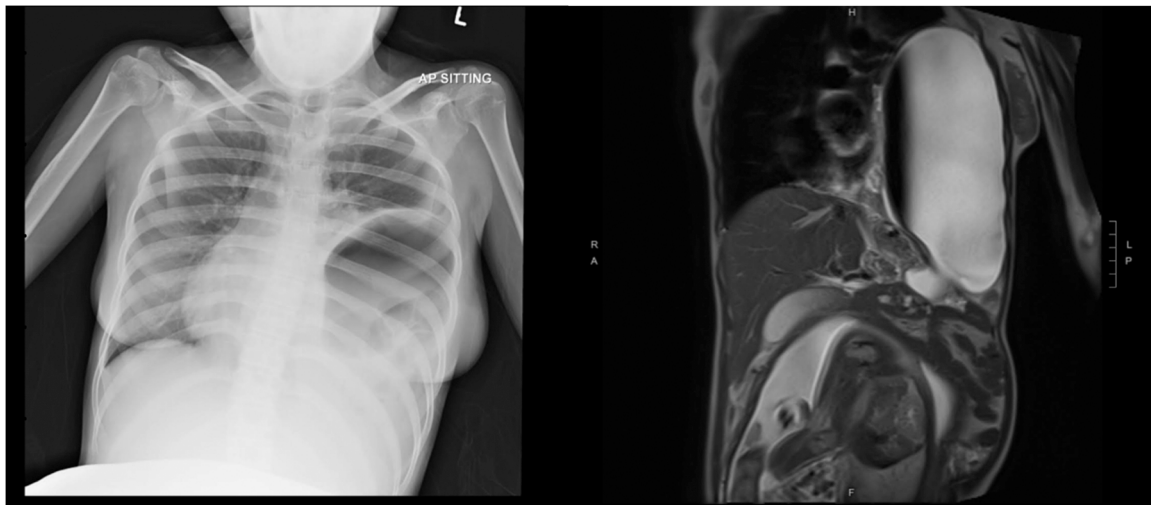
Chest x ray showing upward displacement of the bowel into the left thoracic cavity, and left diaphragmatic hernia confirmed by magnetic resonance imaging.
